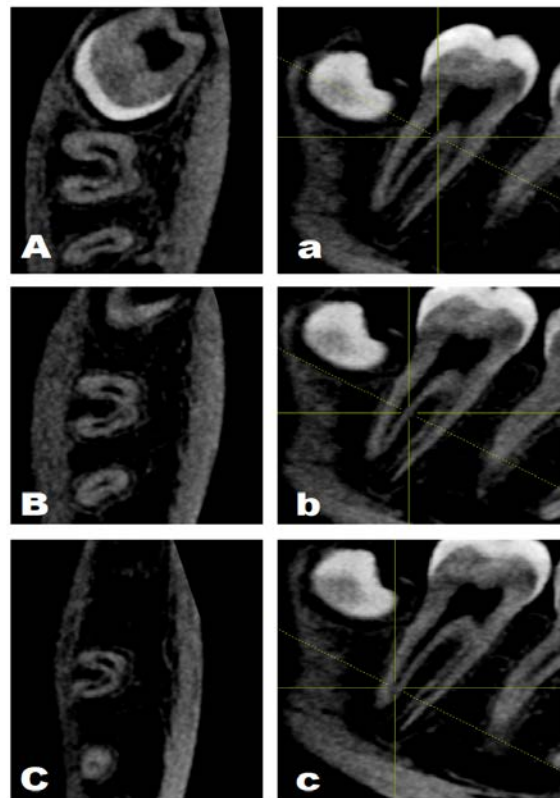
Cone-beam computed tomography (CBCT) axial cross-sections of the left mandibular second molar showing different types of C-shaped canal system (A, B, C) with corresponding levels of analysis on sagittal cross-sections (a, b, c).
